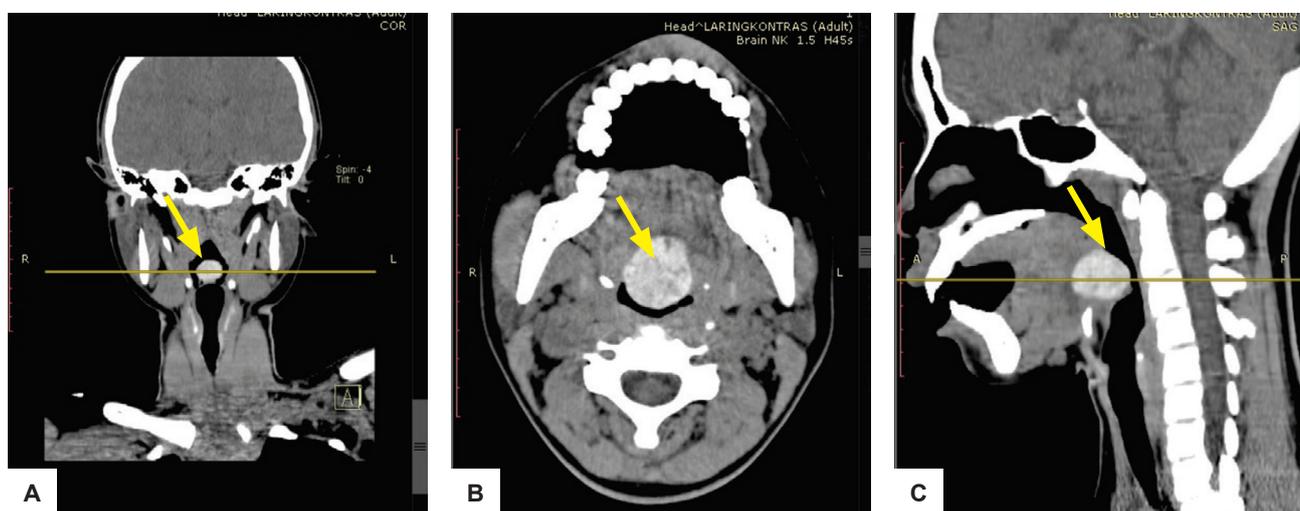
Head and neck CT scan examination. (A) Coronal and (B) axial enhanced neck CT scan demonstrates well-defined homogeneous enhancing mass without calcification (yellow arrows); (C) A sagittal enhanced CT scan of the neck demonstrates enlargement of the thyroid gland. It shows the location of the thyroid gland above the normal thyroid (sublingual position) (yellow arrow).
